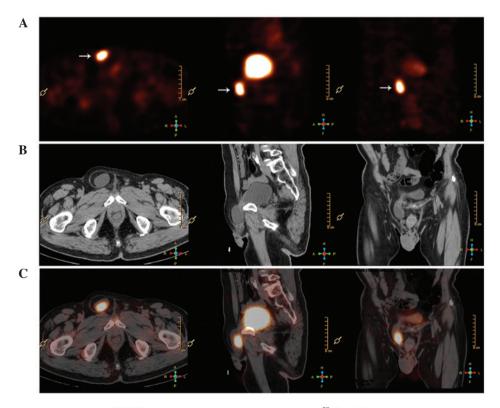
(A) Transaxial, coronal, sagittal SPECT tomography images indicate increased <sup>99m</sup>Tc-MDP uptake in the right inguinal region, which appears separate from the main bladder activity (arrow). (B) CT images of the pelvis show an inferior tongue-like extension of the bladder into the right inguinal region. The neck of the hernial sac was relatively wide, so the hernia contained a homogeneous low-density cyst due to trapped urine. (C) Fused SPECT/CT axial images demonstrate the circular accumulation of <sup>99m</sup>Tc-MDP in the medial right groin and well-defined walls that connect the accumulation to the bladder. SPECT, single-photon emission computed tomography; <sup>99m</sup>Tc-MDP, <sup>99m</sup>technetium-methylene diphosphonate; CT, computed tomography.
